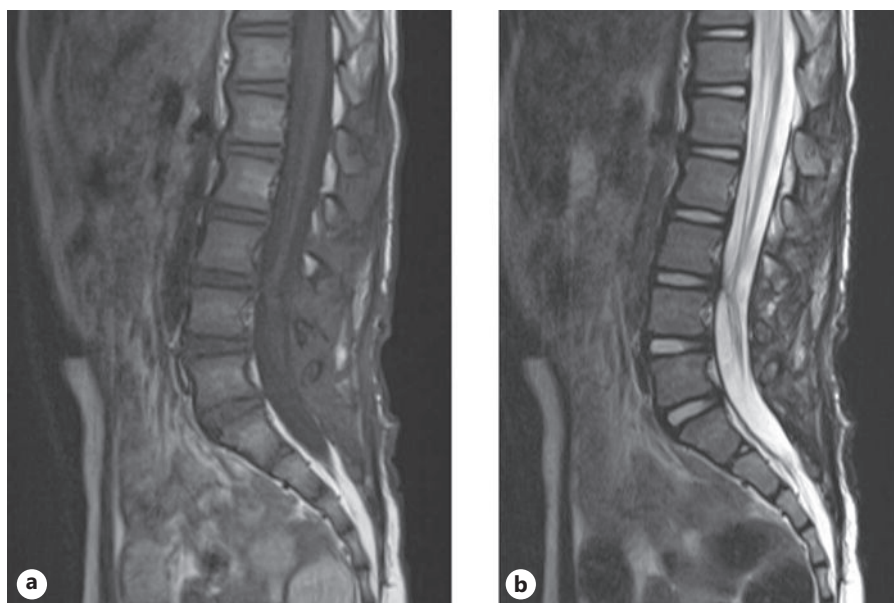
Postoperative MRI, T1-weighted sagittal (a), T2-weighted sagittal (b), revealing that the intraspinal tumor was completely resected and the tumor was left in paraspinal muscles.
